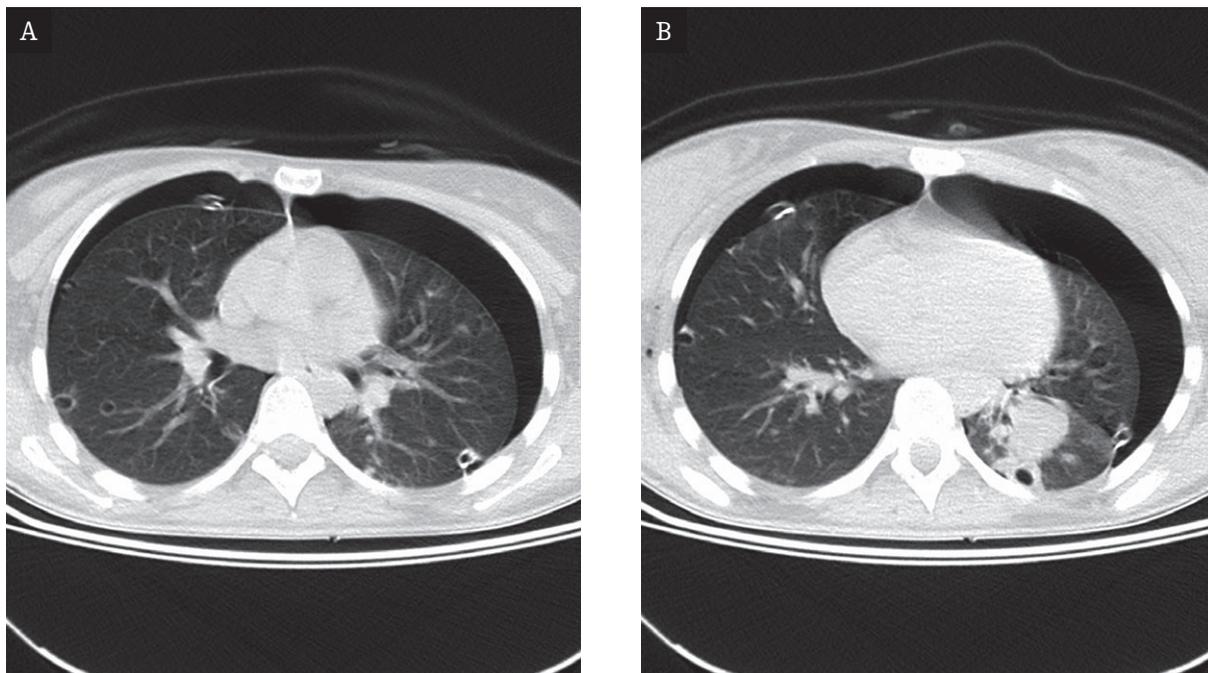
A, B. CT, cystic and solid changes, some of them localized at the margins of the lung tissue. Bilateral pneumothorax.
